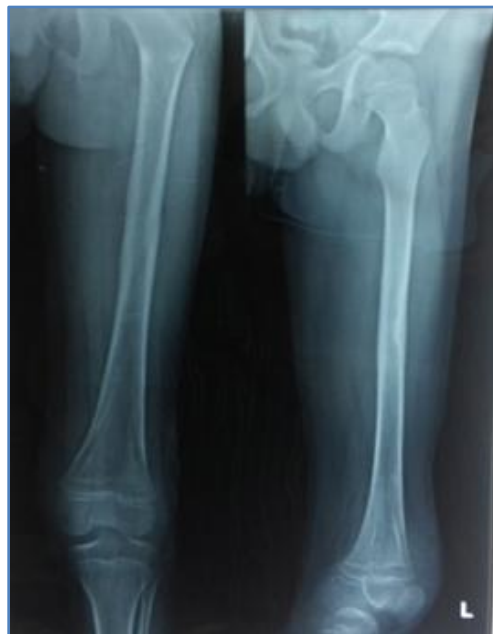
X-ray images of fracture mid shaft femur of 9 year old boy: following implant removal
